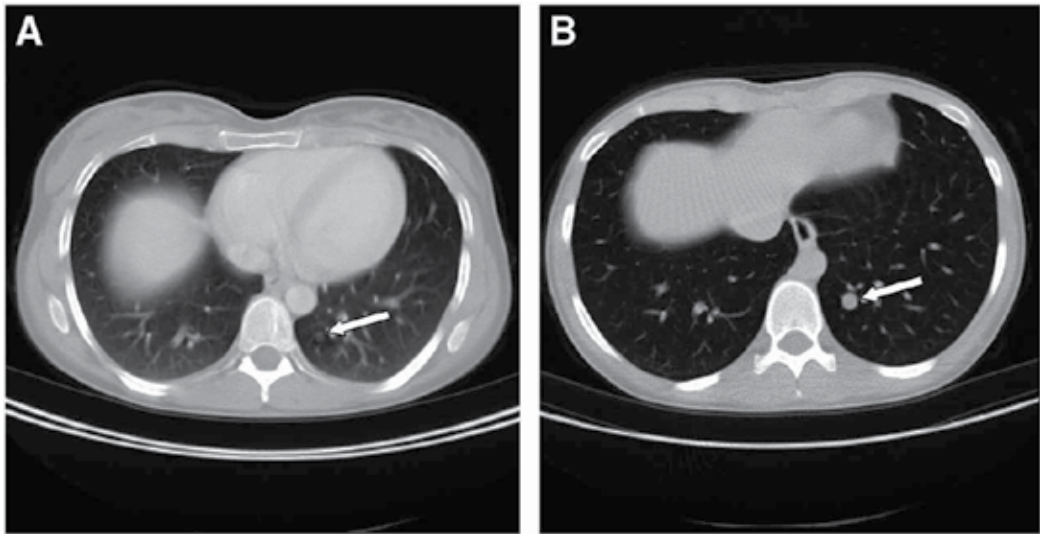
Comparison of chest scanning during shallow breathing (A) and chest scanning with additional low-dose CT during maximal inspiration (B). (A) Lung metastasis from colorectal cancer is only barely visible during shallow breathing (arrow). Also note blurred lung vessels and congested lung parenchyma in this image. (B) Metastasis can be clearly detected by low-dose CT during maximal inspiration (arrow). Additionally, lung parenchyma is well inflated, and lung vessels are displayed sharply. http://jnm.snmjournals.org/content/48/1_suppl/45S/F2.expansion.html
